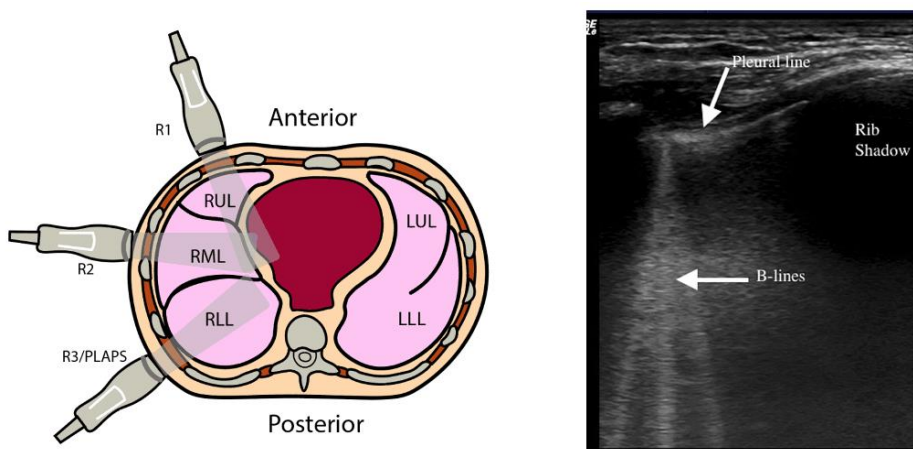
Lung ultrasound. Probe positions showing different projections as a part of a structured protocol examining the lungs. The picture at the right showing the pleural line, rib shadows and B-lines. Reprinted with permission.
